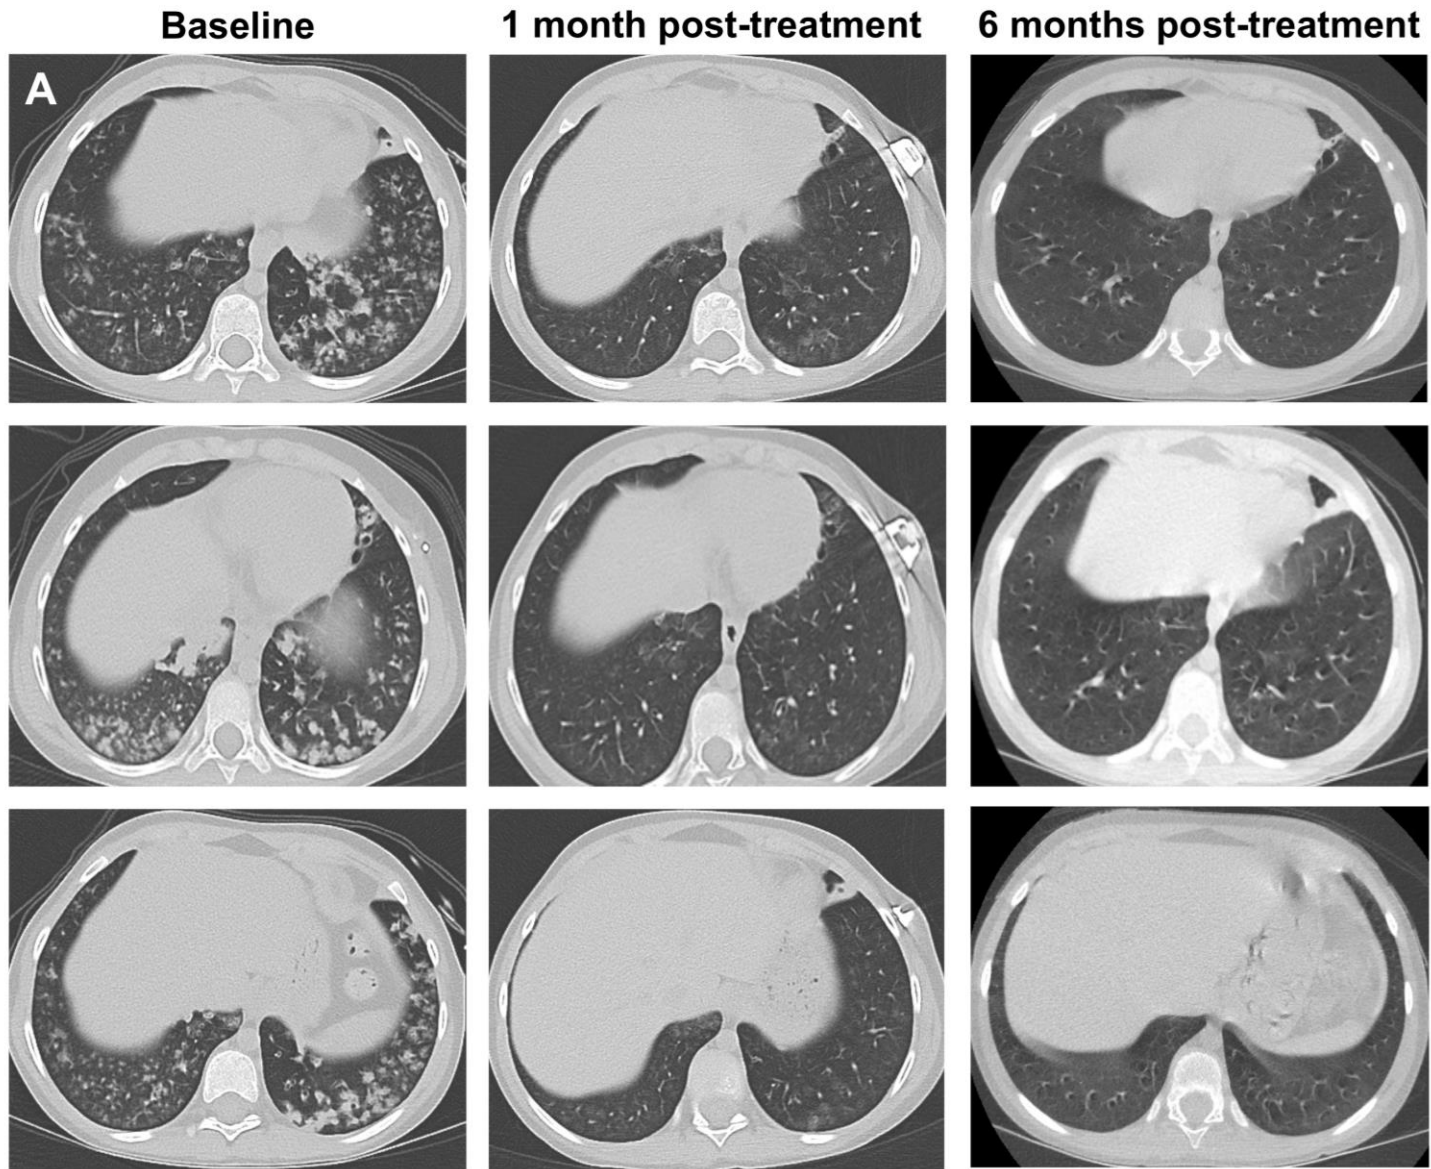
Treatment response assessed by radiography in patient 1. Shown are serial axial (A) and coronal (B) chest CT images and coronal 3D reconstructed CT images (C) at baseline and at 1 and 6 months after treatment initiation.
